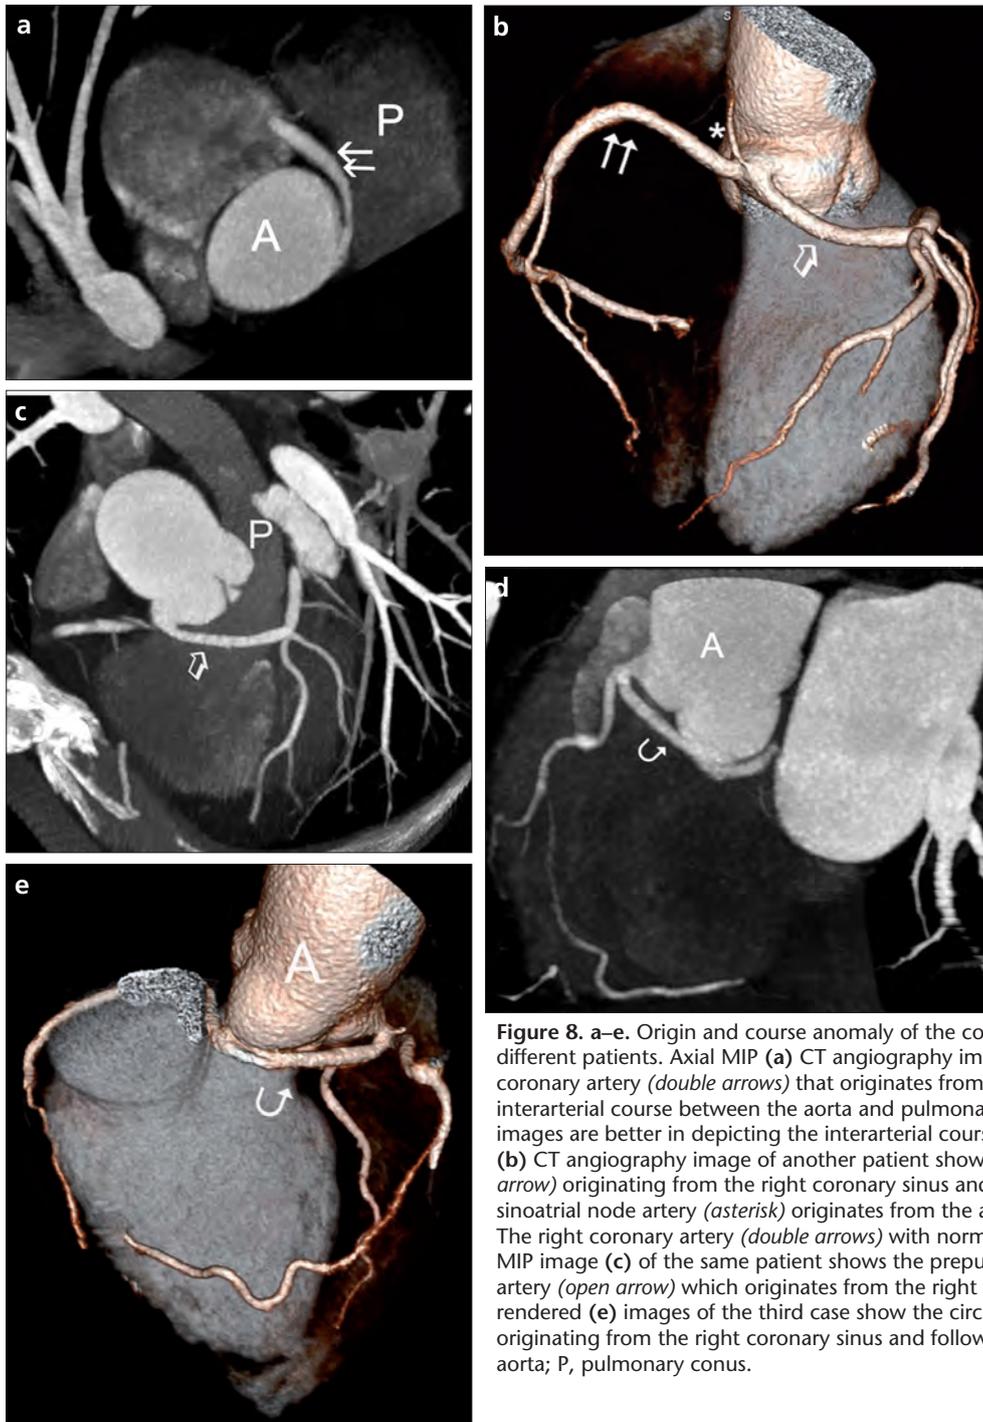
a–e. Origin and course anomaly of the coronary arteries are depicted in three different patients. Axial MIP (a) CT angiography image of a patient displays the right coronary artery (double arrows) that originates from the left coronary sinus and follows an interarterial course between the aorta and pulmonary artery. Axial MIP CT angiography images are better in depicting the interarterial course of the vessel. Volume-rendered (b) CT angiography image of another patient shows the left main coronary artery (open arrow) originating from the right coronary sinus and following a prepulmonic course. The sinoatrial node artery (asterisk) originates from the anomalous left main coronary artery. The right coronary artery (double arrows) with normal origination and course is also seen. MIP image (c) of the same patient shows the prepulmonic course of left main coronary artery (open arrow) which originates from the right coronary sinus. MIP (d) and volume-rendered (e) images of the third case show the circumflex artery (curved arrow) that is originating from the right coronary sinus and following a retroaortic course. A, ascending aorta; P, pulmonary conus.
